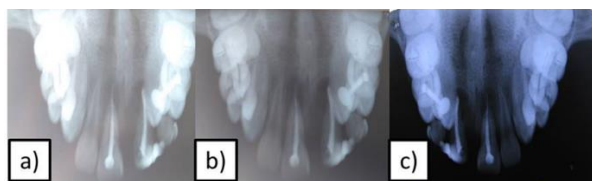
Postoperative radiograph after replantation a) 2 months, b) 4 months, c) 8 months.
